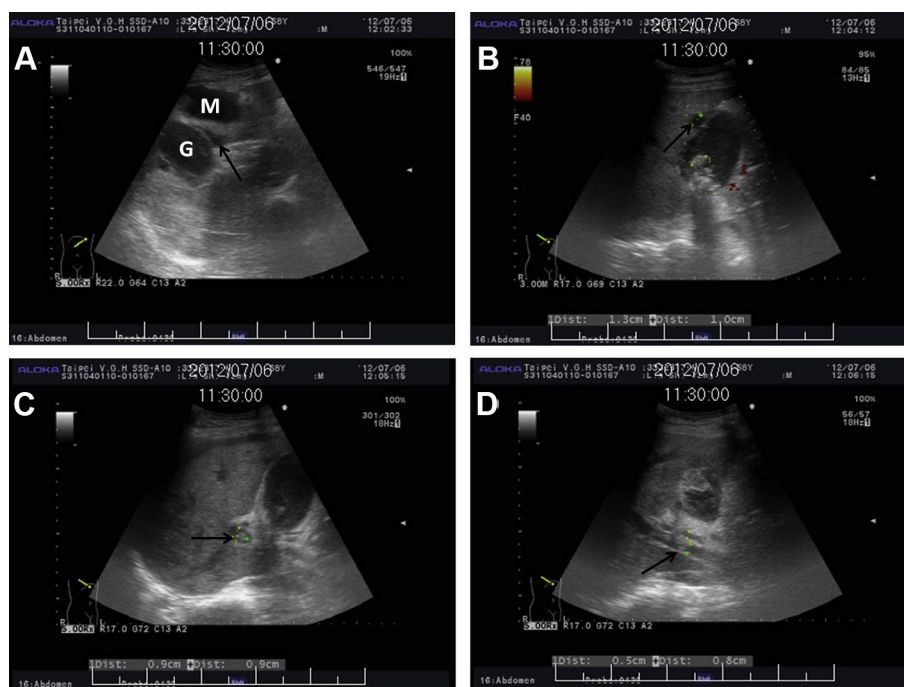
Abdominal ultrasound. (A) One irregular hypoechoic mass lesion (M) 5.5 cm × 6.6 cm in size near the gallbladder (G) and pericholecystic hypoechoic fluid (arrow). (B) Multiple gallstones with acoustic shadow and a small bulging lesion with gallbladder wall defect (arrow). (C, D) Heterogenic contents within the gallbladder and portal vein thrombus (arrow).
